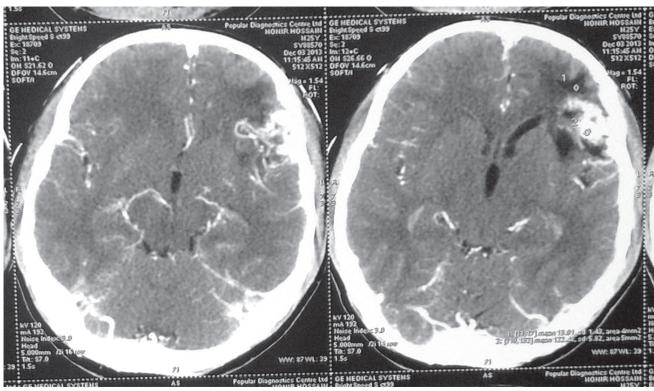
CT scan of Brain showing AVM
